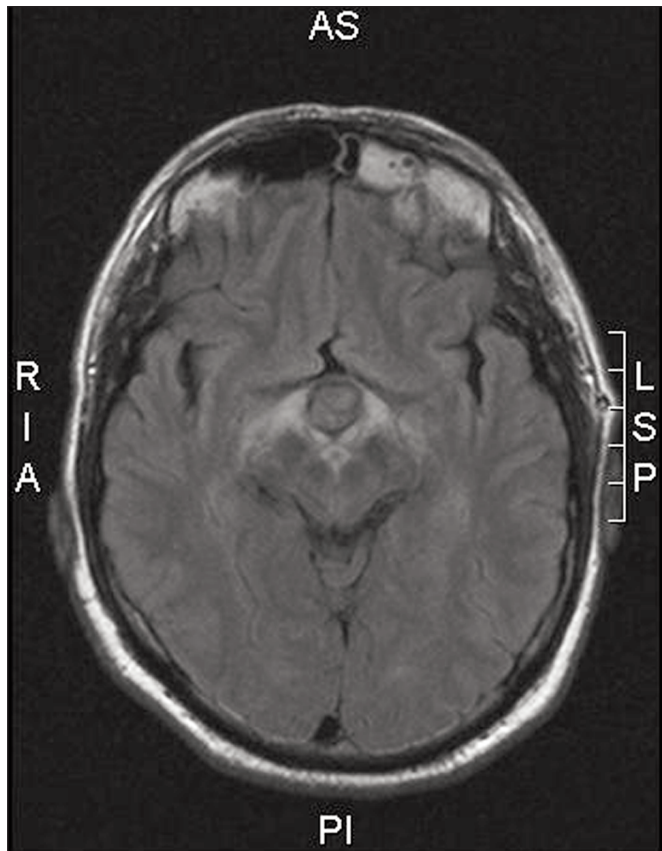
MRI FLAIR Axial.
